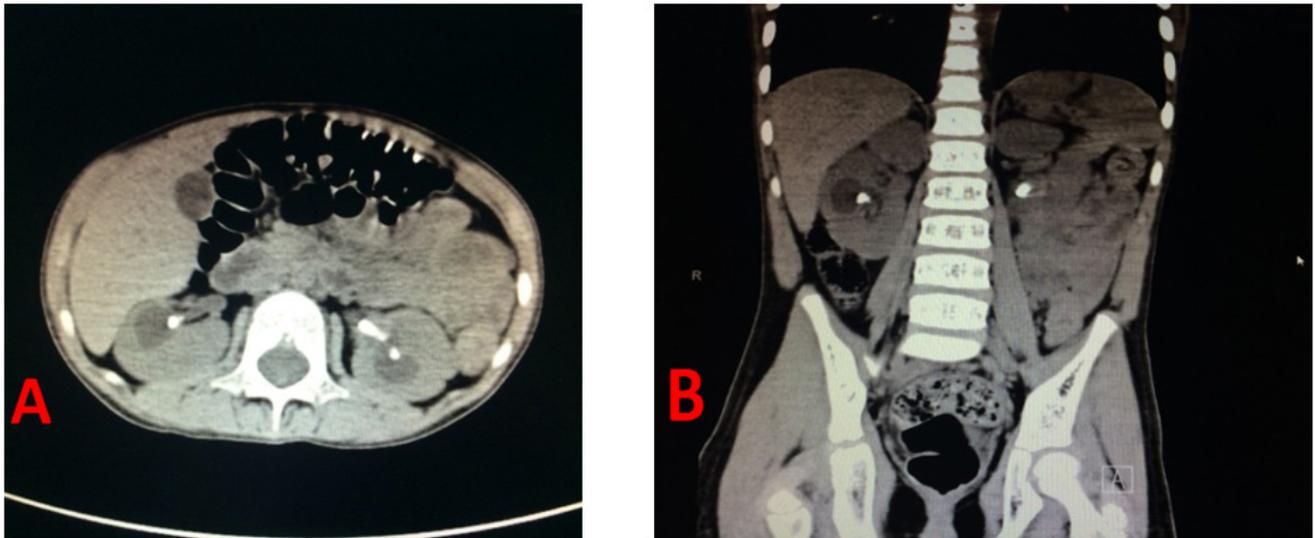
CT scan of the abdomen. (A) Cross section; (B) Longitudinal section, both showed renal stones in both kidneys
